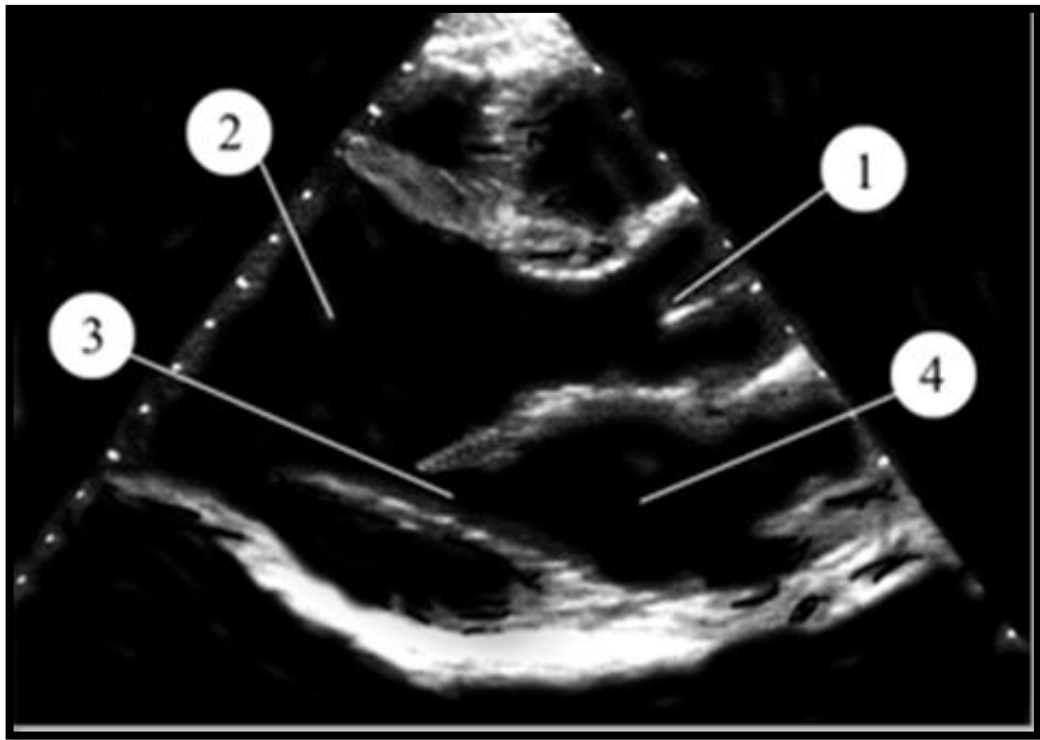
Parasternal long-axis view. Aortic valve (1), left ventricle (2), mitral valve (3), left atrium (4).
